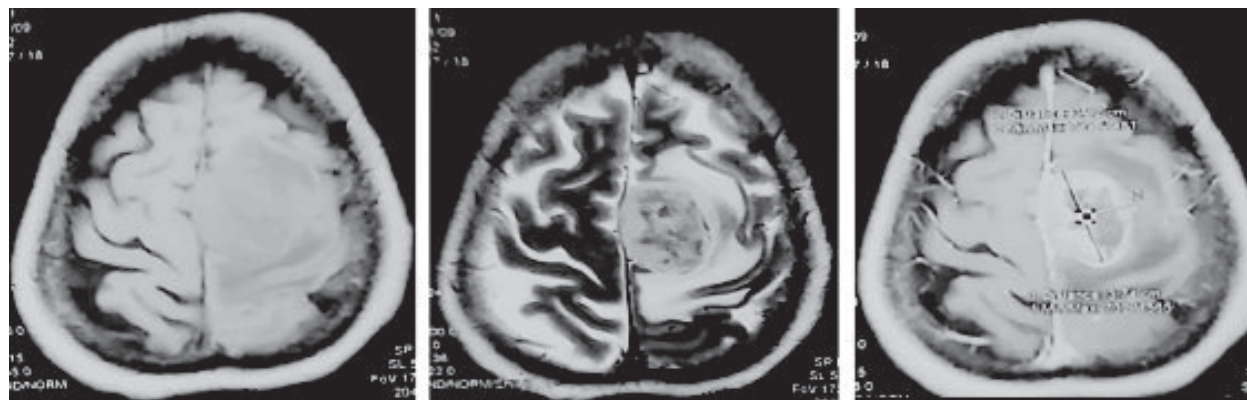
(Left image): showing Hypo intense lesion on T1W pre contrast axial MR image of left para sagittal meningioma and 3b(middle image): showing the lesion as hyper intense on T2W image and Fig 3c(Right image): Showing strong heterogeneous enhancement of the lesion.
